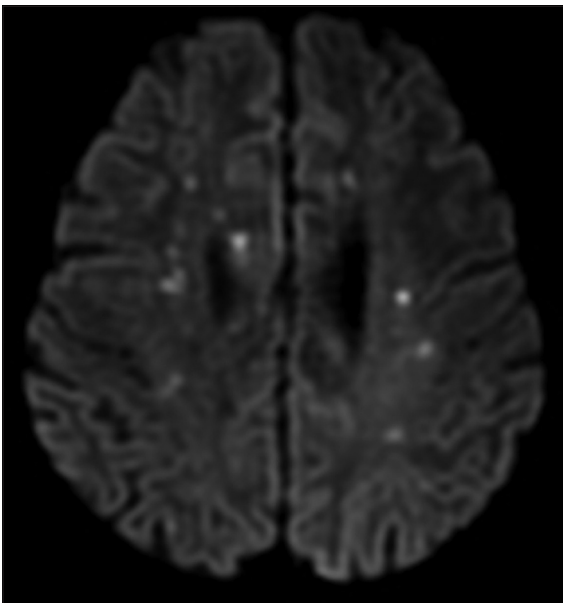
DW MR image shows bilateral asymmetric areas of restricted diffusion in the white matter of both frontal and parietal lobes.
